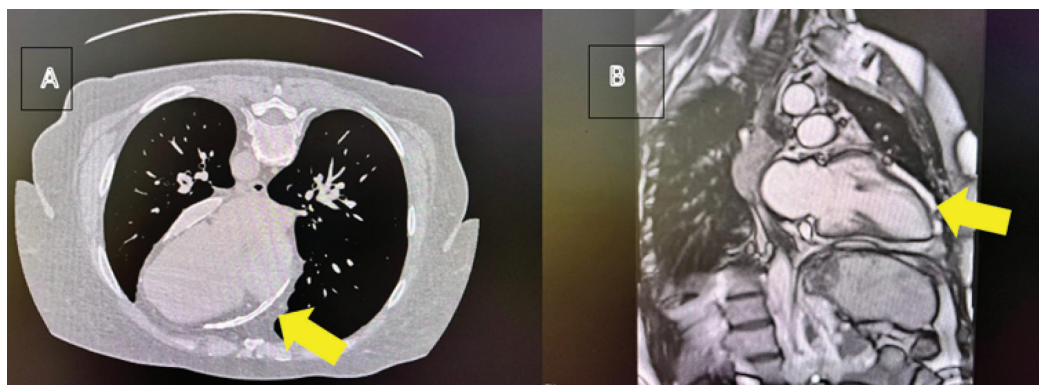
A. CT coronary angiography showed an almost completely thickened (up to 15 mm) and diffusely calcified pericardium. B. Magnetic resonance of the heart showed signs of constrictive pericarditis, with potential pericardial sarcoidosis.
